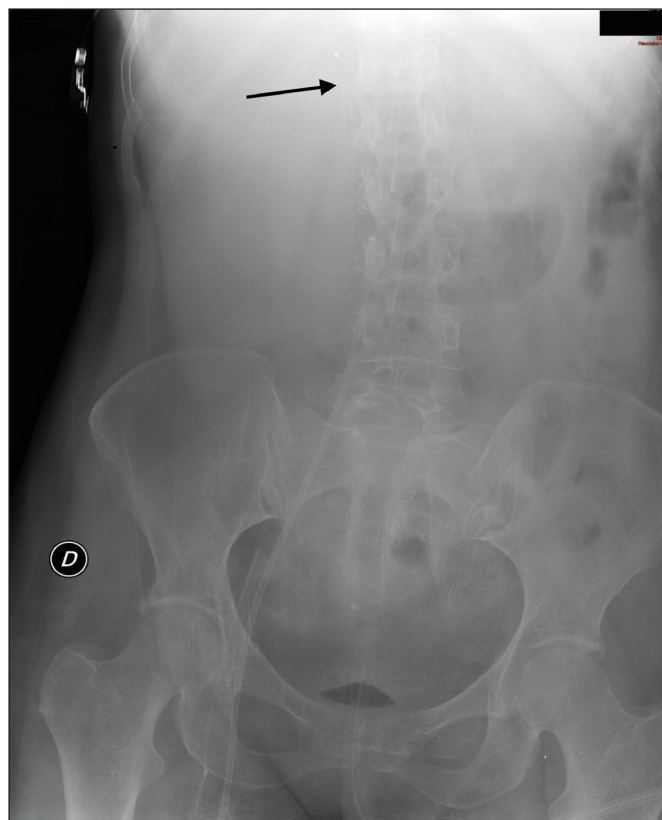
Position of Angel Catheter on X-ray. The catheter is inserted via the right femoral vein and the tip is positioned at the level of the junction between the first and second lumbar vertebrae (arrow).
